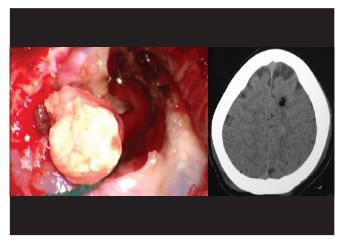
Intraoperative photograph showing the lesion next to the cortical incision and postoperative CT brain scan showing successful removal of the lesion
